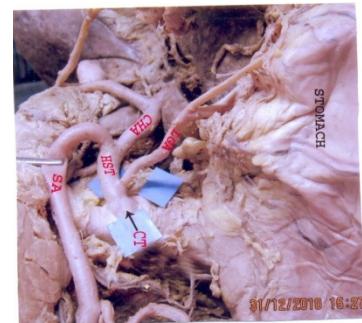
showing origin of left gastric artery as a first branch of coeliac trunk. CT- Coeliac trunk, SA-Splenic artery, CHA-Common Hepatic artery, LGA- Left gastric artery, HST-Hepato-splenic Trunk
